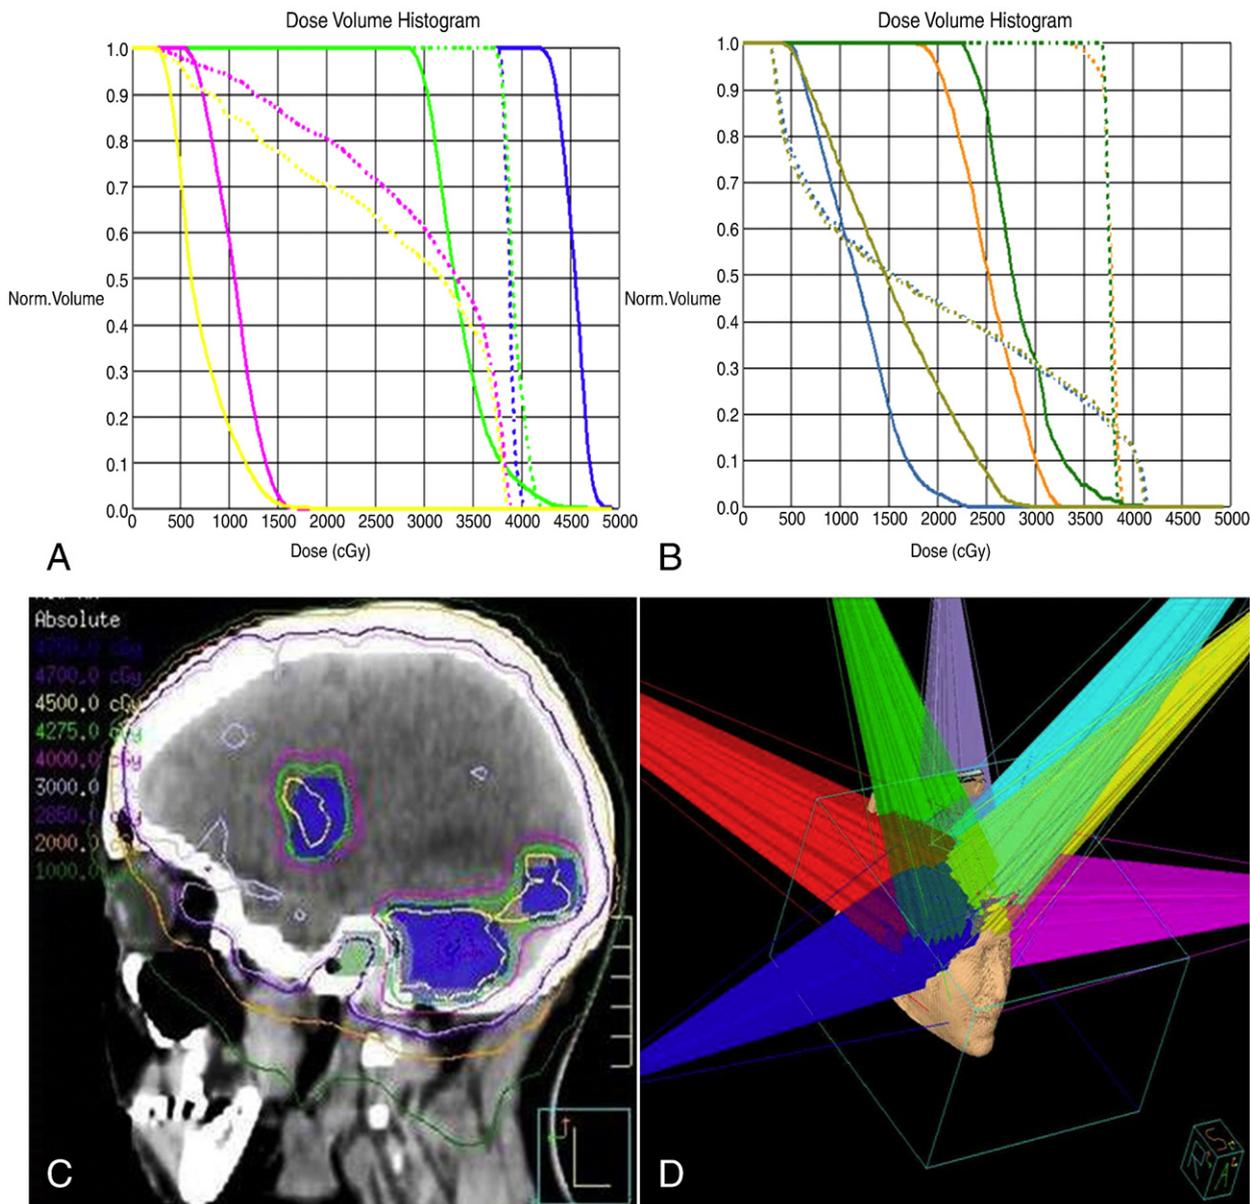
Sample treatment planning for simultaneous integrated boost (SIB) with the prophylactic whole-brain technique. To highlight the extent of organ sparing we demonstrate dose volume histograms comparing the plan for a sample patient using both SIB and conventional whole brain radiation therapy. (A) Planning target volume (PTV) boost (blue), PTV whole-brain (green), right-left parotid (magenta-yellow). (B) Right-left cochlea (green-orange), right-left eye (blue-gold). (C) Computed tomographic planning images showing absolute dose prescription isodose lines with dose to boost PTV of 45 Gy (gross tumor volume of gross metastases plus 2-3 mm margin) and lower “prophylactic” dose to whole-brain of 30 Gy all in 15 fractions with optimized sparing of organs at risk: cochlea, parotid, scalp, lens, etc. (D) Single isocenter, 5-10 non-coplanar beam arrangement for SIB technique.
